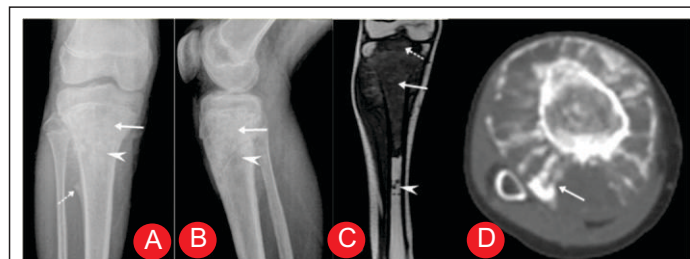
Conventional high-grade osteosarcoma. Anteroposterior (AP) (A) and lateral (B) radiographs show a sclerotic lesion in the (straight arrow) in the upper tibial metaphysis, with permeative margins (arrow head) and a Codman triangle (dotted arrow). (C) Coronal T1-weighted image shows a large, low signal mass in the upper tibial metaphysis (straight arrow) involving the epiphysis with distal skip lesions (arrow head) (D) Axial CT image shows an extraosseous mass (arrows), which is circumferentially surrounding tibia with spiculated and sunburst type of periosteal reaction, destroyed cortex and osteoid density in surrounding soft tissue.
